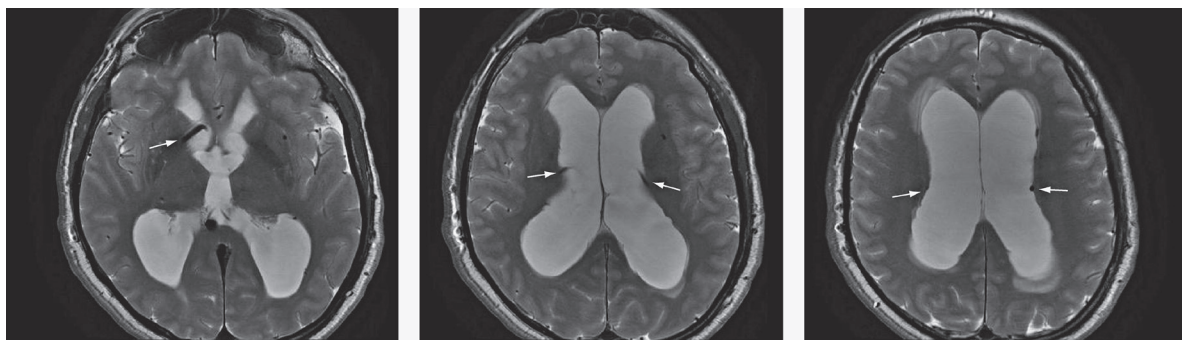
Axial T2-weighted MRI performed at the time of presentation to medical attention. Note the bilateral demonstration of engorged periventricular and transmedullary veins (arrows).
